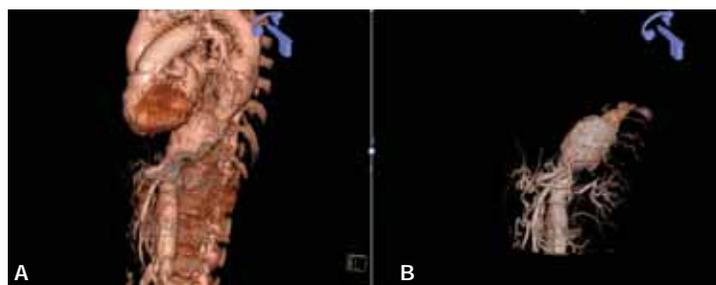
(A) shows a previous 3D CT study superimposed on (B) current 3D angiographic study, which can be fused into the current live fluoro to allow real-time continuous road mapping capability.
